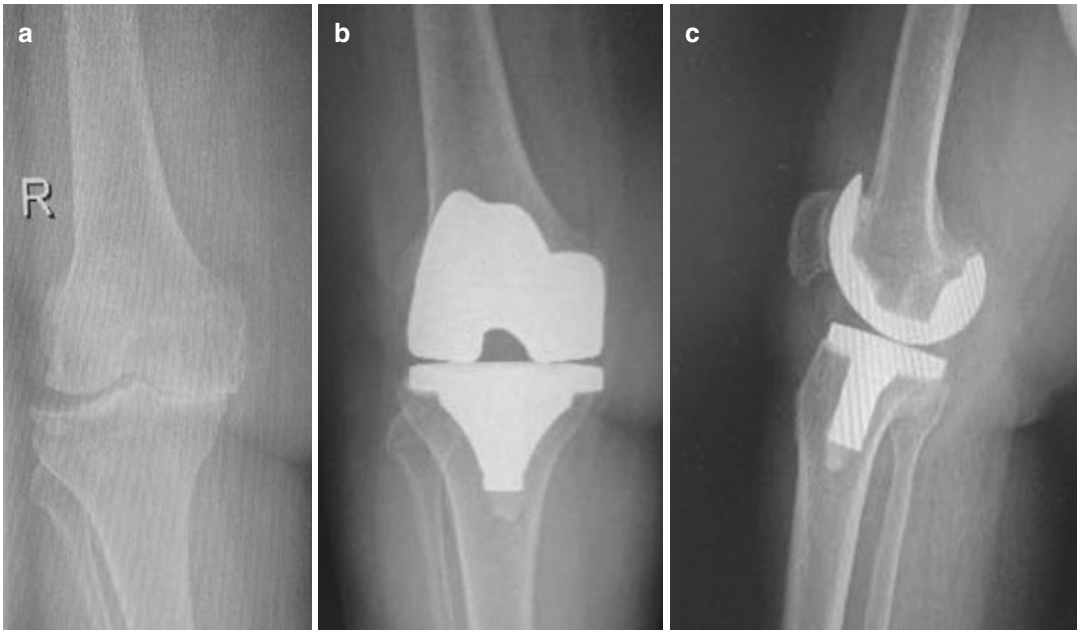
(a–c) Pain and deformity due to the cartilage erosion of the knee joint (a) that require a total knee arthroplasty in a RA patient with the postoperative AP (b) and lateral radiographies (c)
